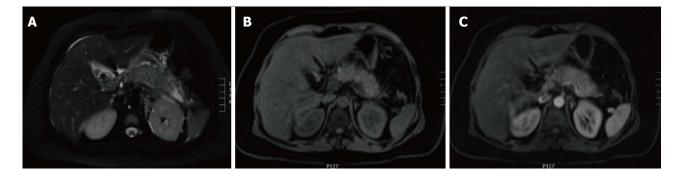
Gallstone acute edematous pancreatic tail pancreatitis. A: Axial fast spin-echo (FSE) T2-weighted image with fat-suppression; B and C: Post-contrast 3D-GRE T1-weighted images with fat-suppression during the late arterial and portal venous phases. There is mild diffuse lace-like increased T2 signal involving the pancreatic parenchyma, associated with a small amount of peripancreatic fluid near the pancreatic tail (A). The pancreas demonstrates diffuse minimal decrease in T1 signal intensity (B) and minimally reduced enhancement on the late arterial phase (C) in keeping with diffuse edematous pancreatitis. There are also innumerable gallstones (A).
